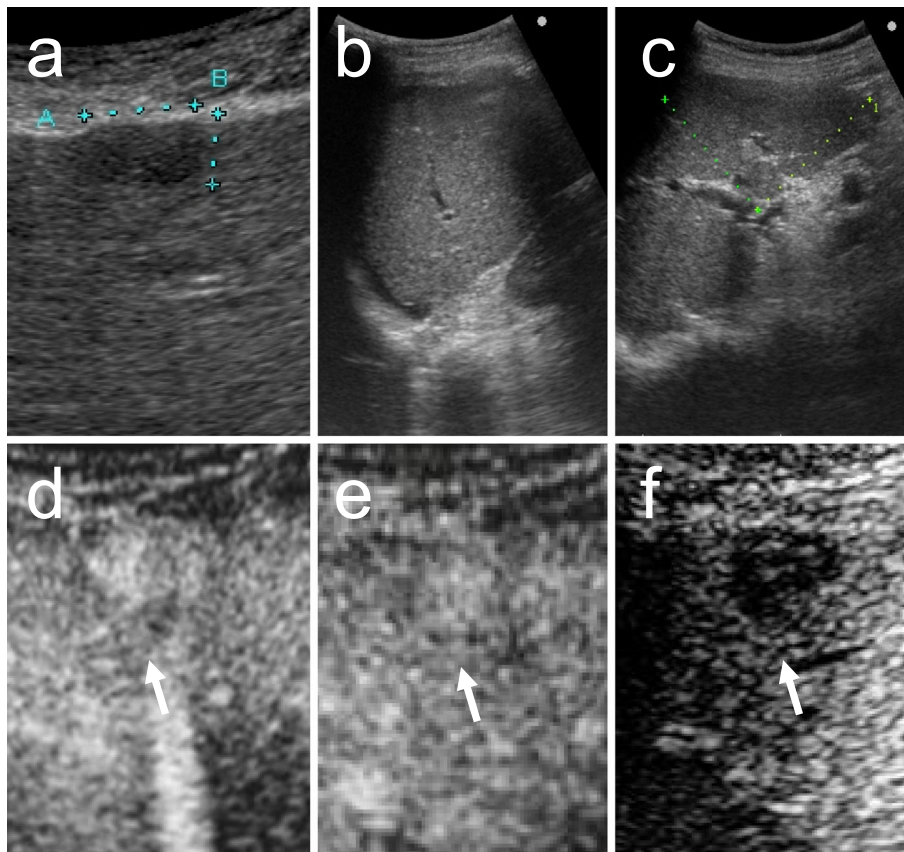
Ultrasonography findings (arrows). B-mode conventional ultrasonography showed a 15 mm hypoechoic mass in liver segment 4 (S4) (a), the liver parenchyma had a coarsened appearance consistent with cirrhosis, and ascites and splenomegaly were observed (b, c). CEUS using Sonazoid showed a homogeneously enhanced mass in the arterial dominant phase (d), a hypoechoic mass relative to the adjacent liver parenchyma during the portal dominant phase (e), and a contrast defect with a clear border in the postvascular phase (f).
